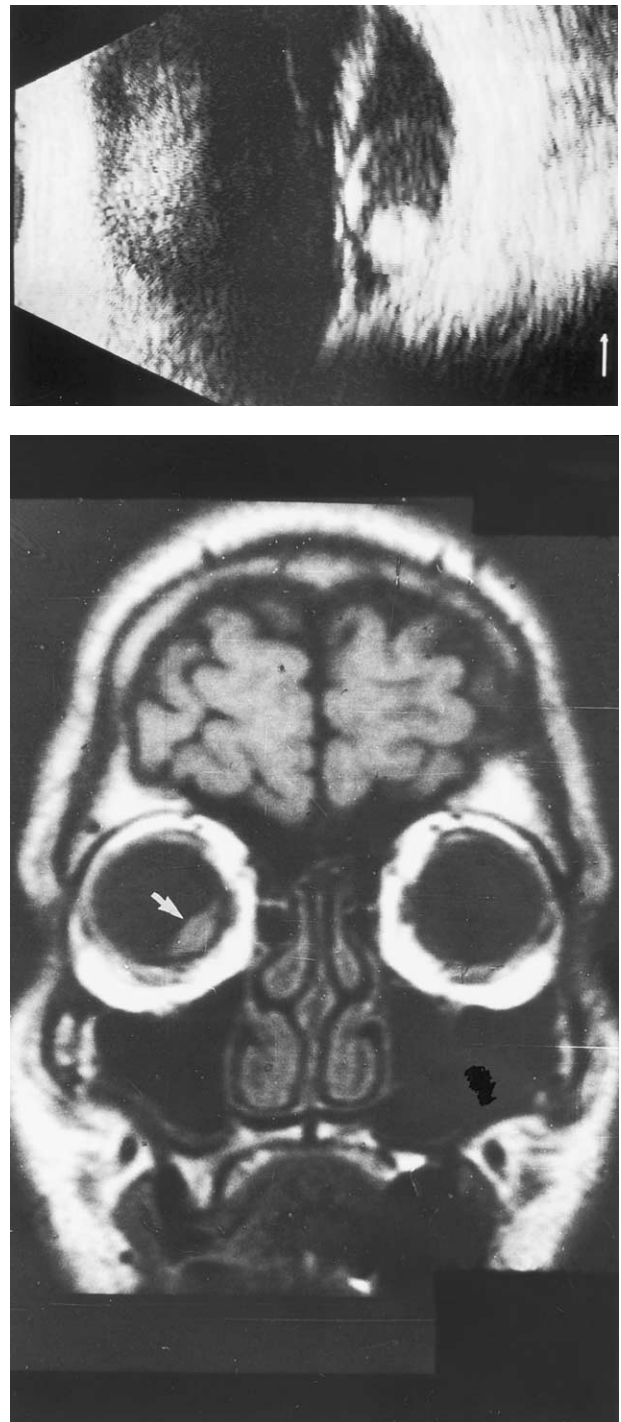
(Top) B-mode ultrasonography showing the intraschisis hemorrhage. The vitreous and the choroid are seemingly not involved. (Bottom) T_1 -weighted coronal cranial magnetic resonance imaging showing a hyperintense lesion in the inferonasal quadrant of the right eye (arrow). As such, the mass is not distinguishable from a melanoma.
